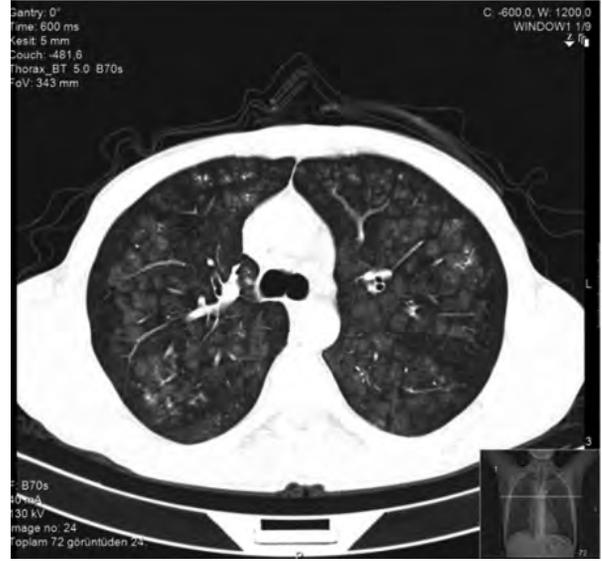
Initial thorax computed tomography
